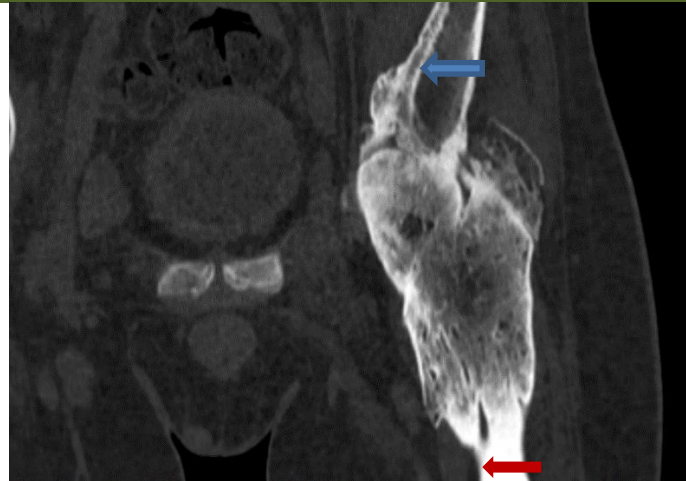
Pelvic CT scan: Coronal view showing voluminous osseous excrescences originating from the iliac wing (blue arrow), extending to the anterior acetabular wall and the left femoral diaphysis (red arrow)
